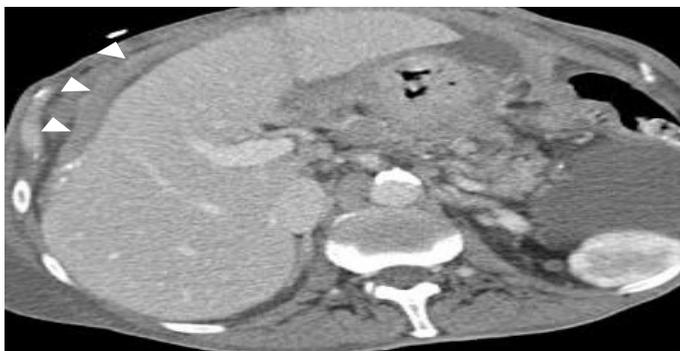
Abdominal contrast enhanced computed tomography images in transverse plane. There is enhancement of the diaphragmatic surface of the liver by mildly enhancing soft tissue (arrowheads)
